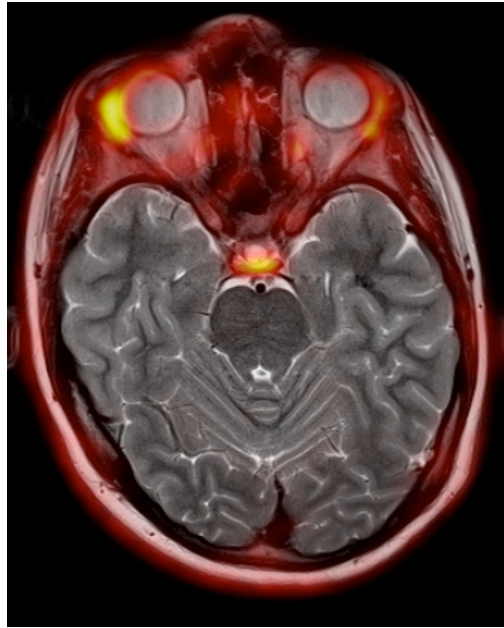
Simultaneous 18F-ethylcholine PET/MR scan at the level of the pituitary gland: axial T2-weighted image demonstrating physiological uptake in the pituitary gland
